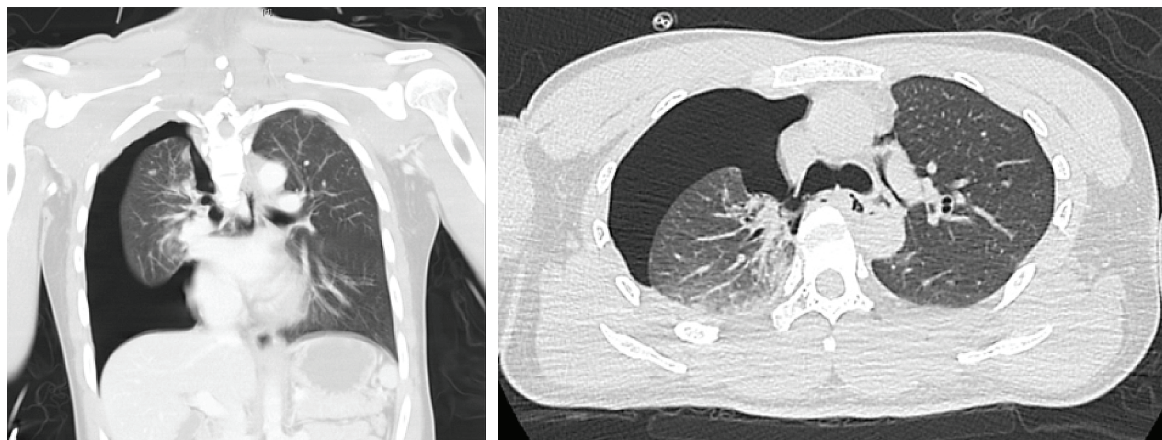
Chest CT showed right pneumothorax with a collapsed right lung.
